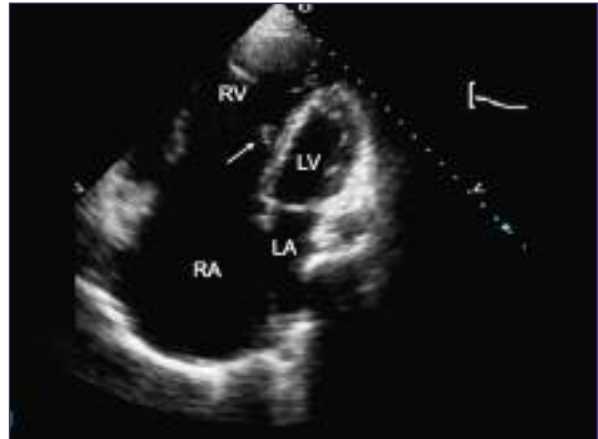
An apical four chamber view on transthoracic ECHO demonstrating apical displacement of the septal leaflet of the TV (arrow) with atrialization of the RV consistent with Ebstein's anomaly. RA, RV, left atrium [LA], left ventricle [LV].
